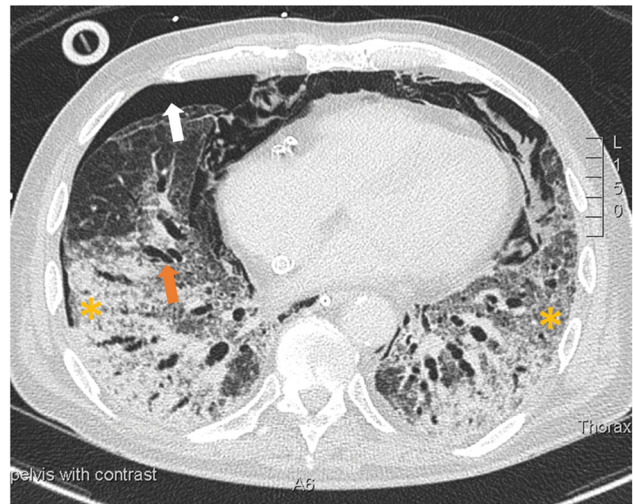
CT scan of the thorax revealing bilateral ground glass changes (*), traction bronchiectasis (grey arrow) and right-sided pneumothorax (white arrow).
